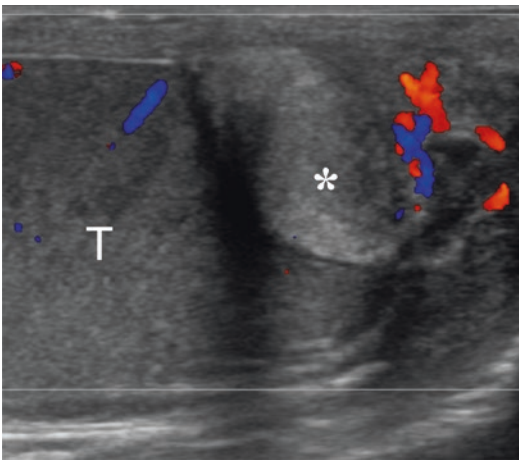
Surgically proved adenomatoid tumour of the tail of the epididymis presenting as a small, echogenic mass (*asterisk*) hypovascular at colour Doppler interrogation. The testis (*T*) is normal
